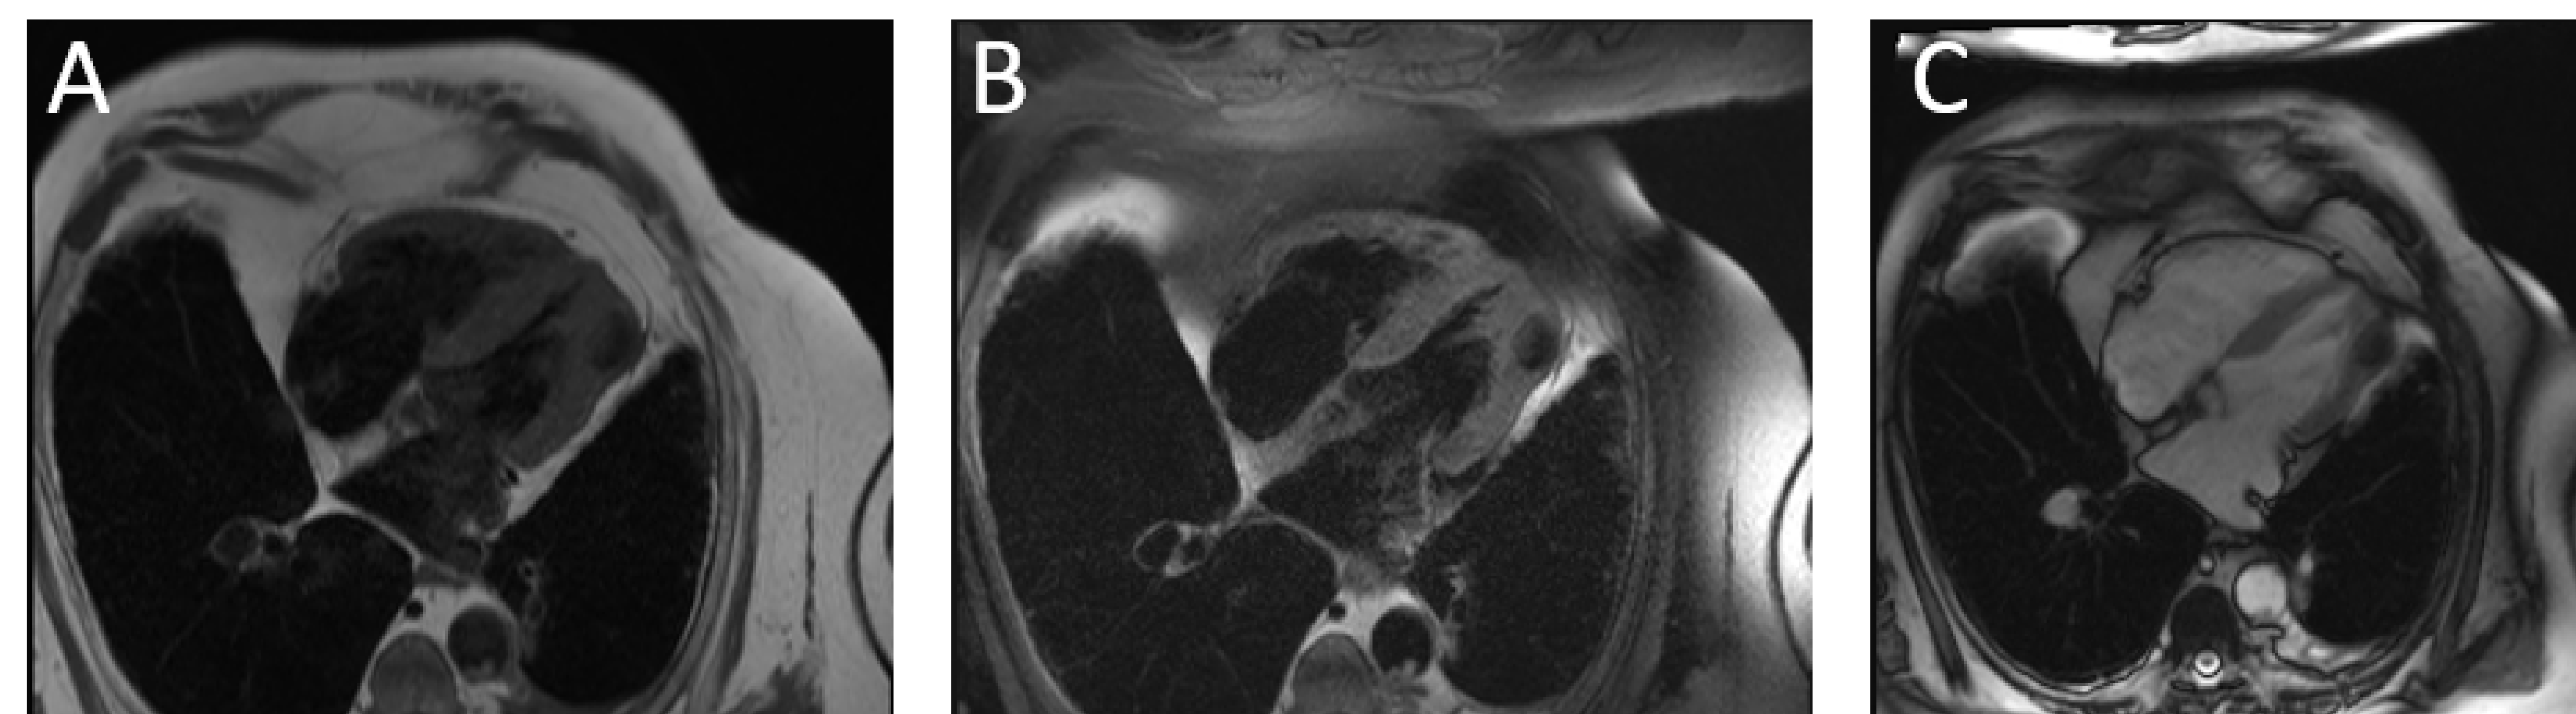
depicts 3 MRI images taken of the tumor
